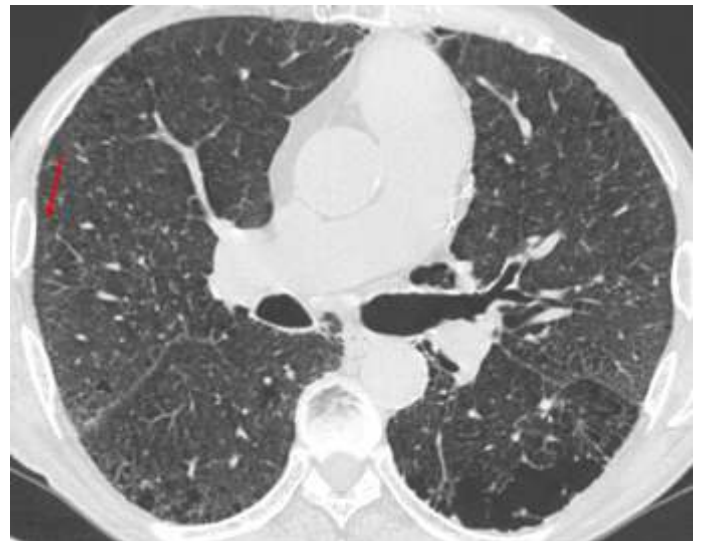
Respiratory bronchiolitis (RB). Axial CT at the level of the carina shows ill-defined distal bronchocentric opacities, characteristic of respiratory bronchiolitis (RB).
